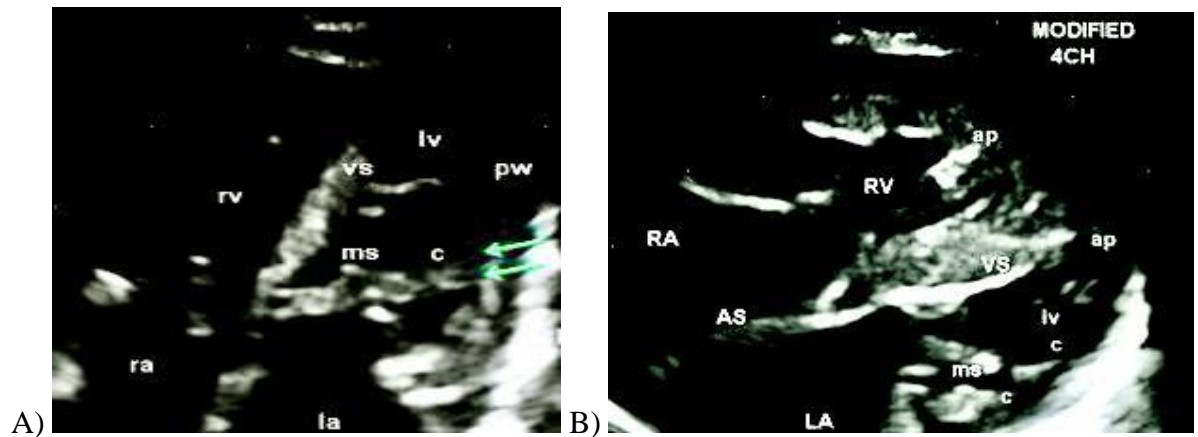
A) In the apical 4CH view no papillary muscles were discerned and the chordae were directly inserting into the posterior wall. B) In the modified 4CH view similar findings were present. la, left atrium; ms, mitral stenosis; c, chordae; pw, posterior wall; lv, left ventricle; vs, ventricular septum
